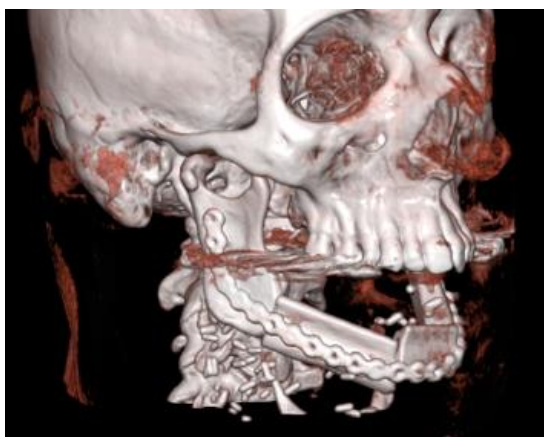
Segmented CT demonstrating a large segmental mandibulectomy defect reconstructed with fibula flap with multiple osteotomy sites, secured with custom pre-bent reconstruction plate.
